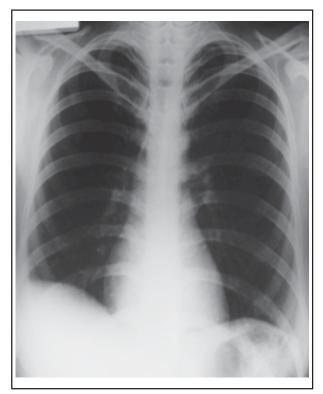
Chest X-ray of the case after corticosteroid therapy. The lesion almost disappeared.
